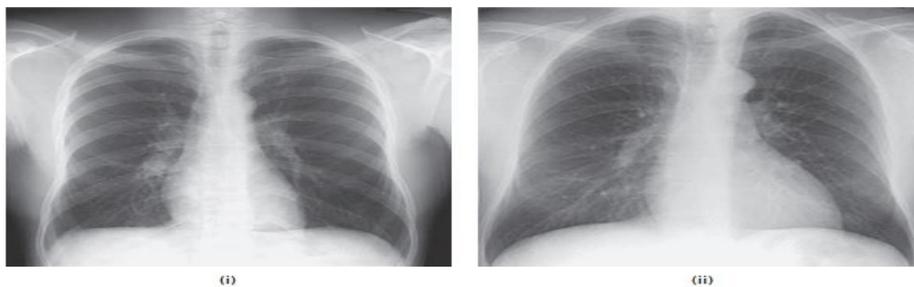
Posterior–anterior chest radiographs of (i) a normal patient and (ii) a patient suffering from tuberculosis.
